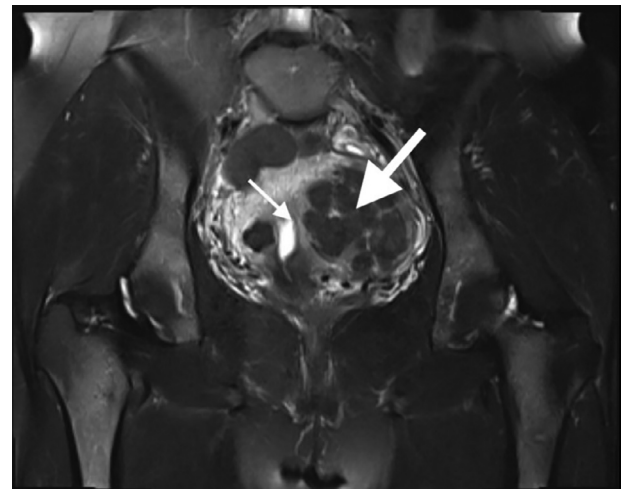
Pre-embolization state (2017) T2-weighted MRI coronal fat saturated view shows heterogeneous myoma (thick arrow) and intact endometrium and myoma interface (thin arrow).
